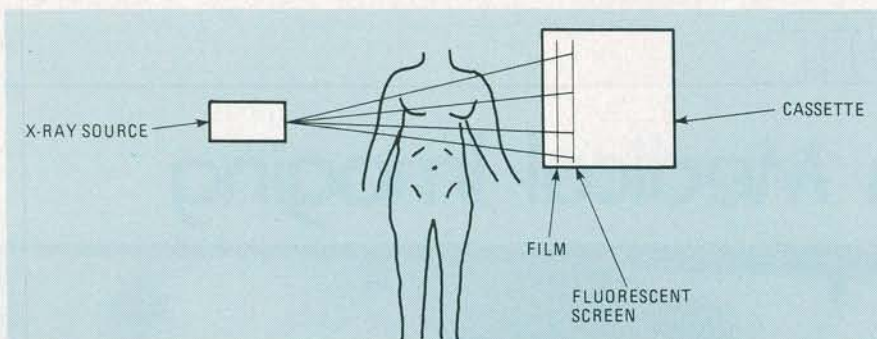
ROUTINE CHEST X-RAY'S are taken using the arrangement shown. Note that the film is located in a cassette that also has a fluorescent screen.
